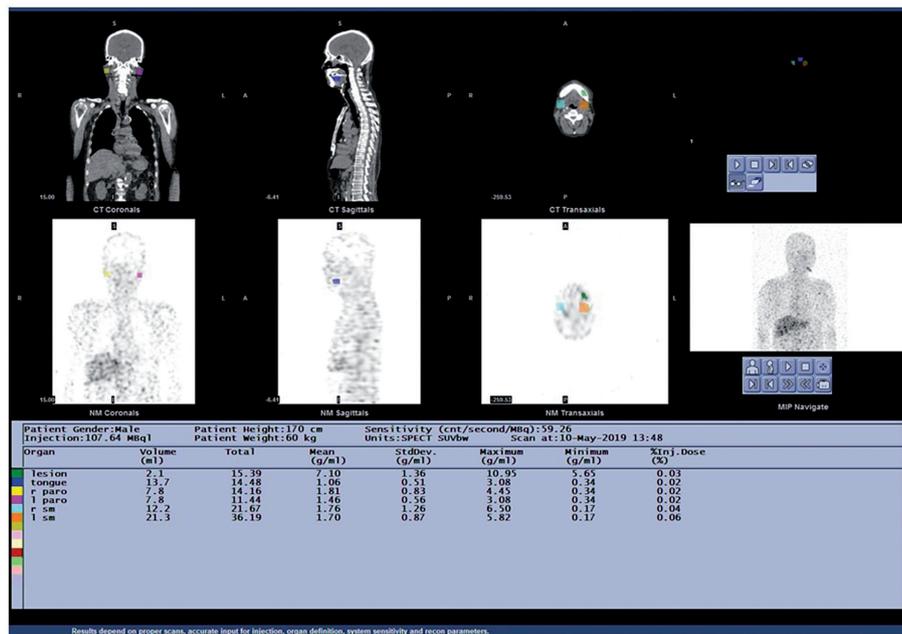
Osteomyelitis of the left side of the mandible in a 66-year-old male. By using the transaxial single-photon emission tomography (SPECT) and computed tomography (CT) as the anatomical reference, a volume of interest (VOI) was drawn over the lesion (green), right parotid gland (yellow), left parotid gland (pink), right submandibular gland (sky blue), and left submandibular gland (orange). The dosimetry software provided multiple quantitative data for a given VOI
